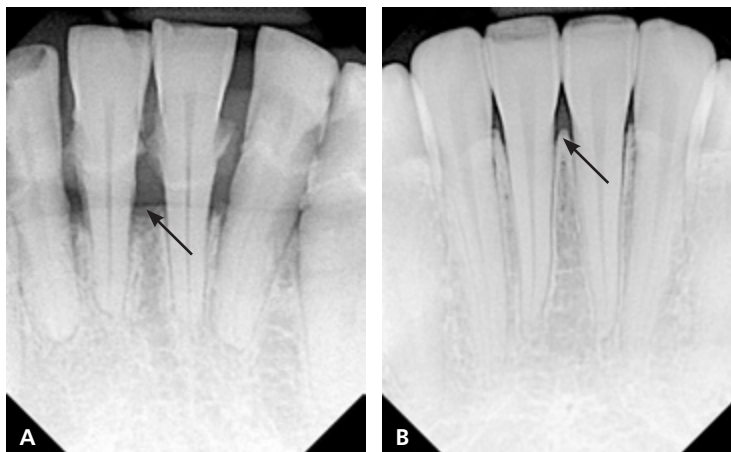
Radiographs of (A) alveolar bone loss in periodontitis (arrow) compared with (B) normal alveolar bone structure (arrow).
